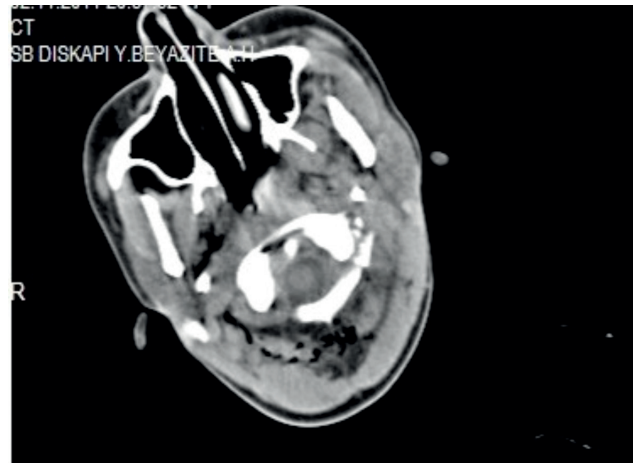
The servical CT ; fracture was detected on the left posterior arch and transverse process of the atlas bone
